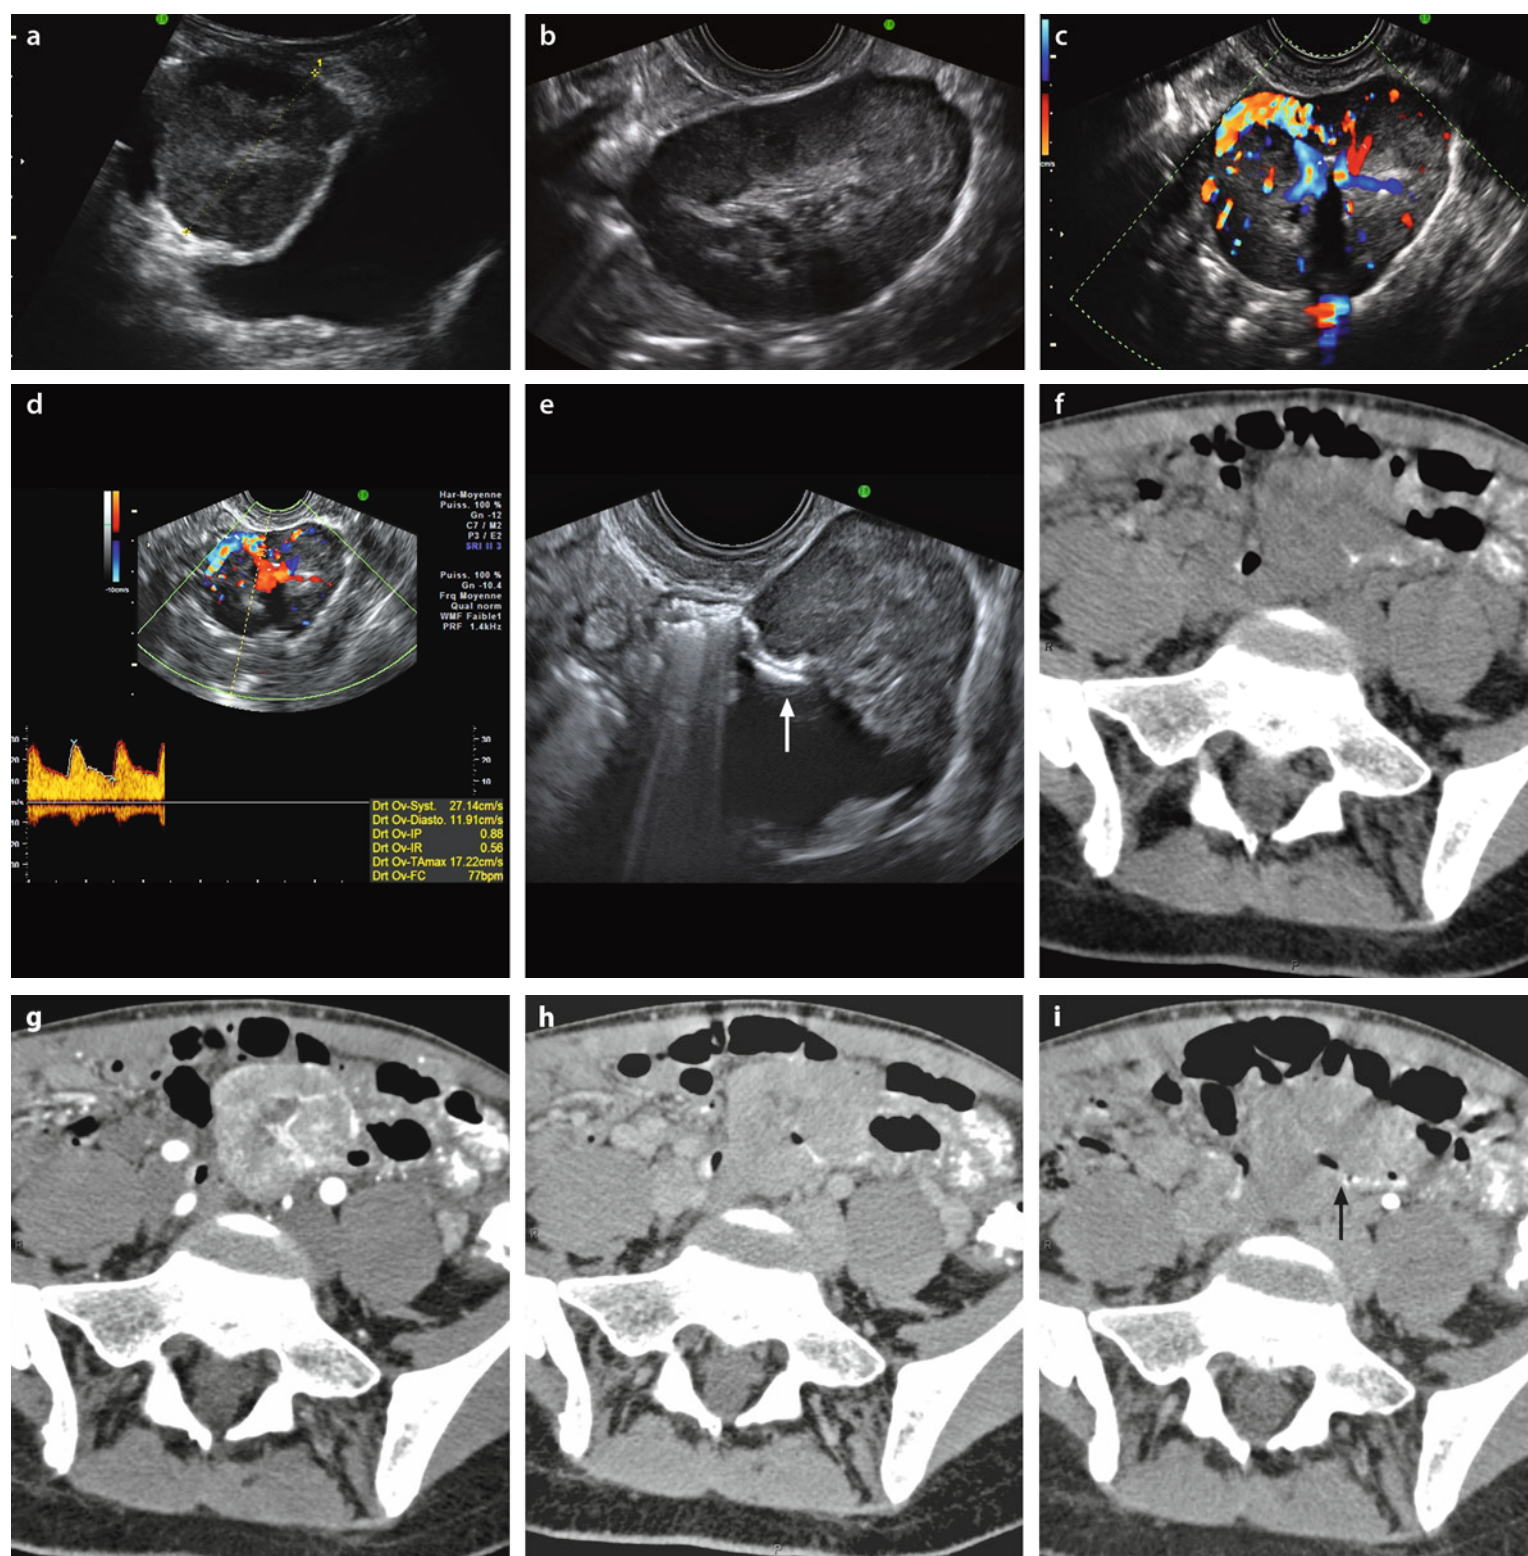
GIST of the small bowel. Thirty-two-year-old woman. During a routine examination, a pelvic mass is discovered. TAS (a), a 4-cm mass in the left portion of the pelvis, close to the bladder is visualized; left kidney lies in the left lumbar fossa and is normal. EVS (b) (1) demonstrates that the mass is extra-ovarian, (2) better depicts the oval shape and the structure of the mass, particularly a central echogenic area. On color Doppler (c), a large pedicle and a high degree of central vascularization are displayed, with a high velocity on pulsed Doppler (d). On (e), gas is entering into the mass
